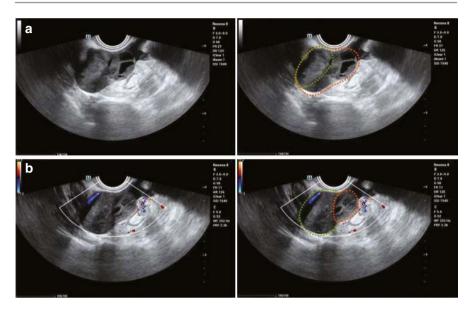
(a) Ovarian tissue is observed surrounding the mass, which has clear boundaries, regular morphology, and is hypoechoic internally. The ovary is circled in orange; the mass is circled in green. (b) Color Doppler ultrasound reveals a small amount of blood flow signals within the mass (pathological testing confirmed the diagnosis as a theca cell tumor). The ovary is circled in orange; the mass is circled in green
